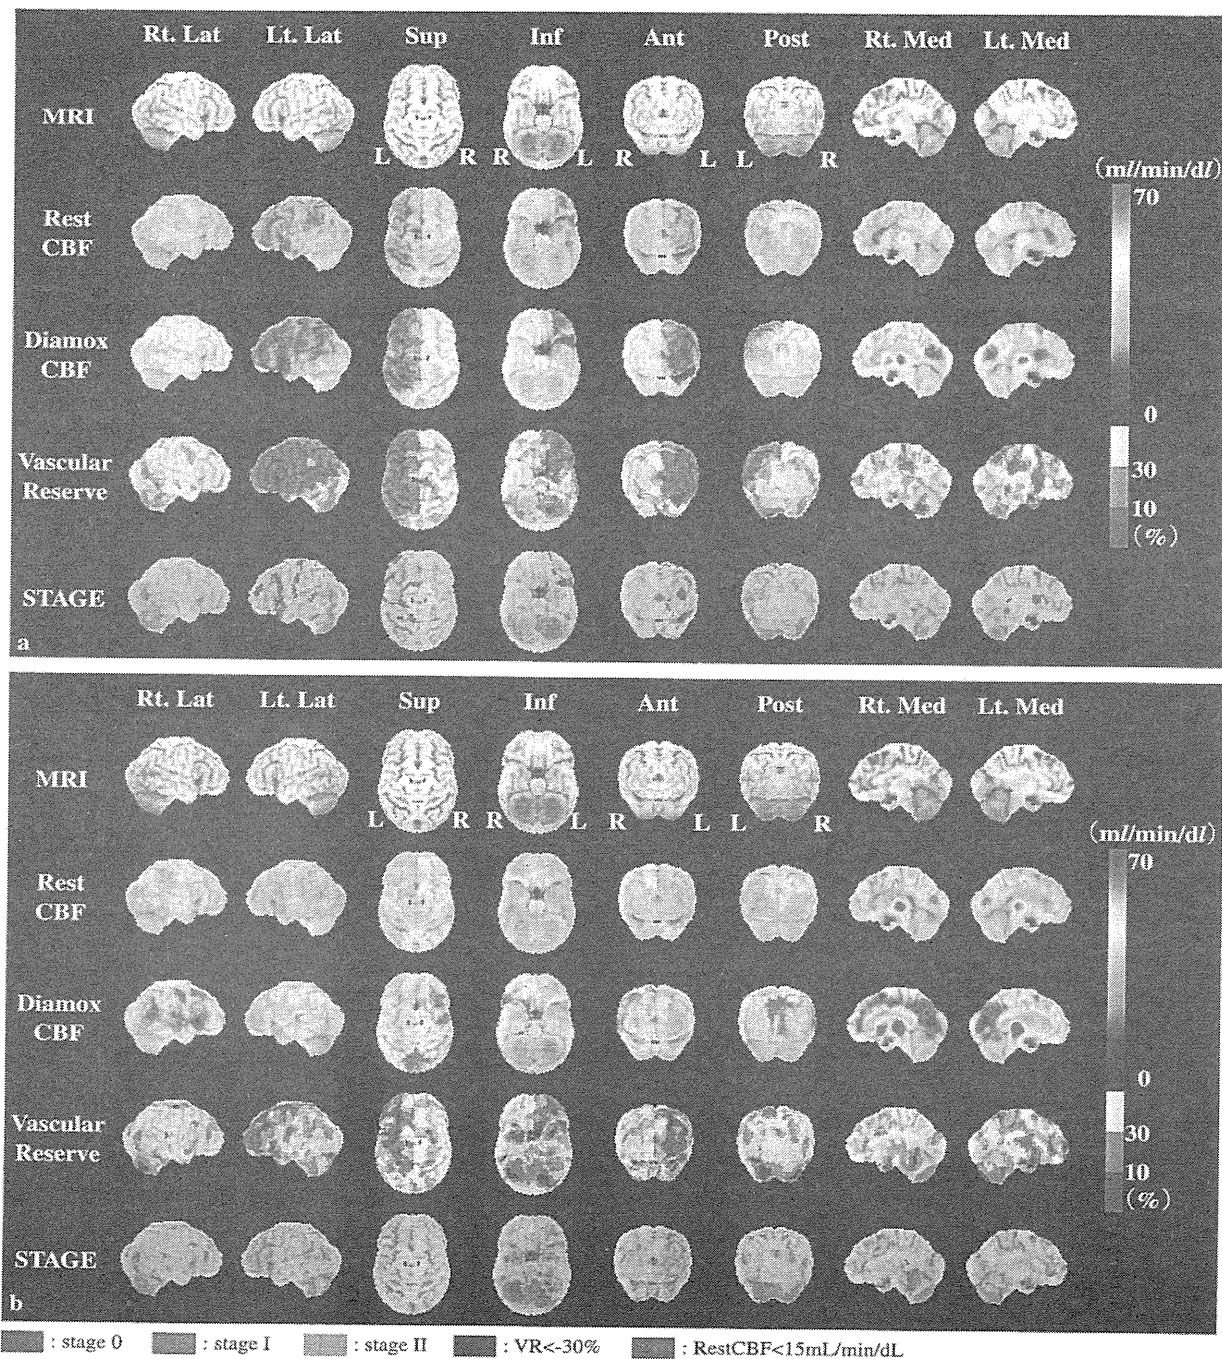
図5の症例での脳血流SPECTのSEE解析
